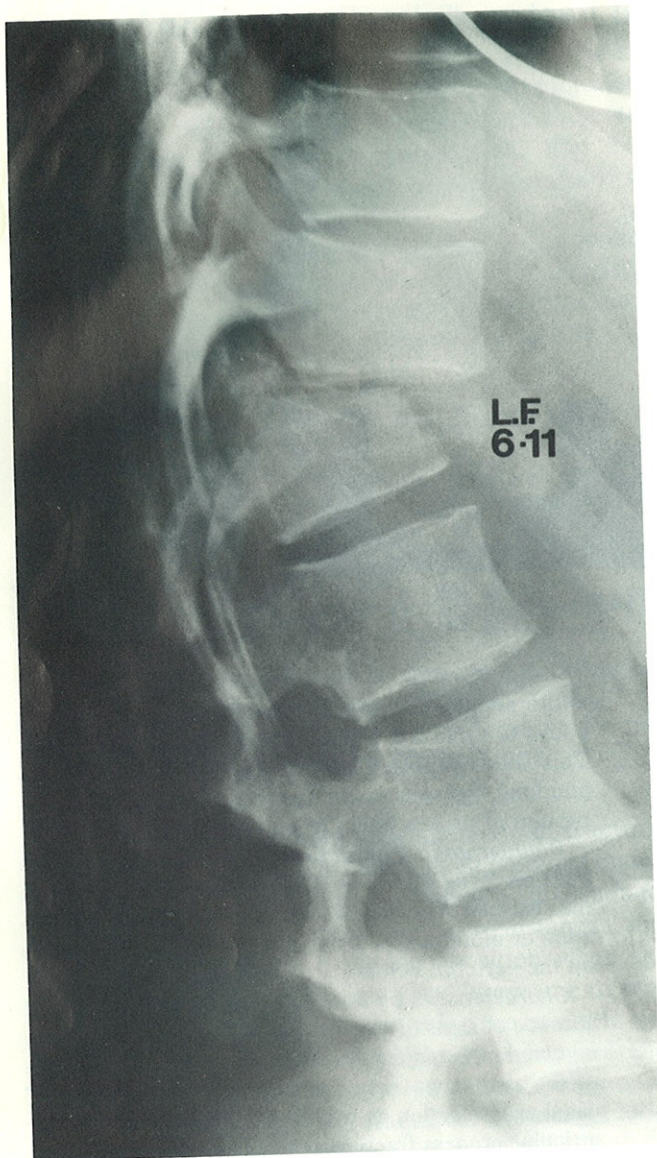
Lateral roentgenogram of a fracture-dislocation of the flexion rotation type through bone (slice fracture).
